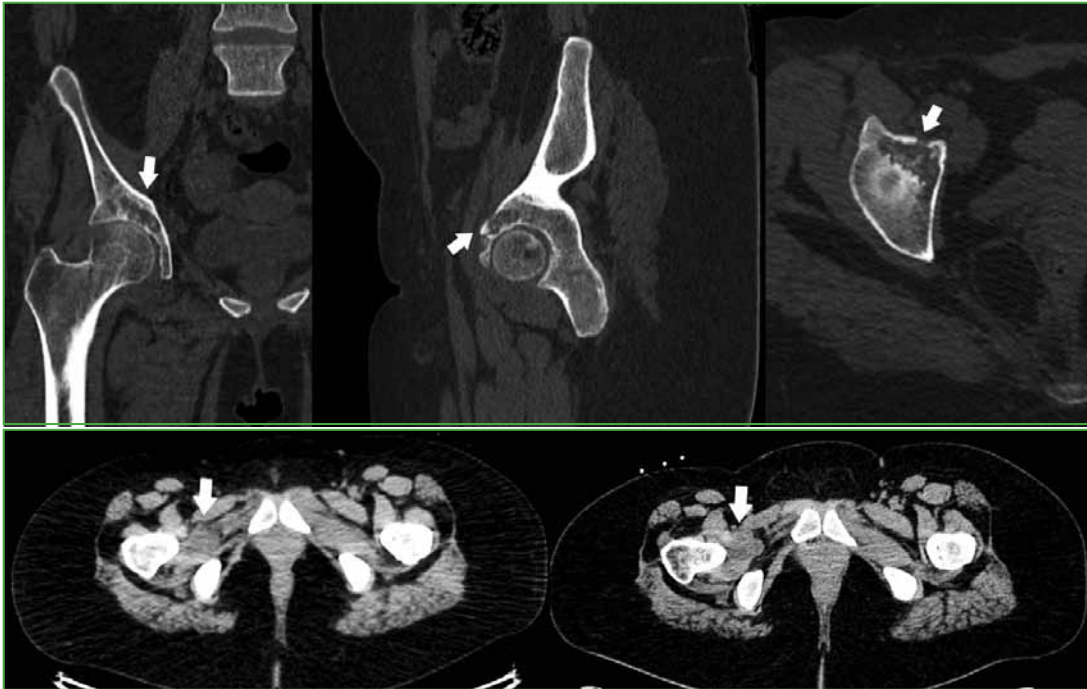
CT scan of the right hip. The progression of the lesion is visualized, now with a lytic component, with compromise of the cortex in the coronal (A), sagittal (B) and axial (C) sections. D. Soft tissue window. When compared to the previous month's study (left), there is a slight increase in the size of the lesion adjacent to the joint (right).
